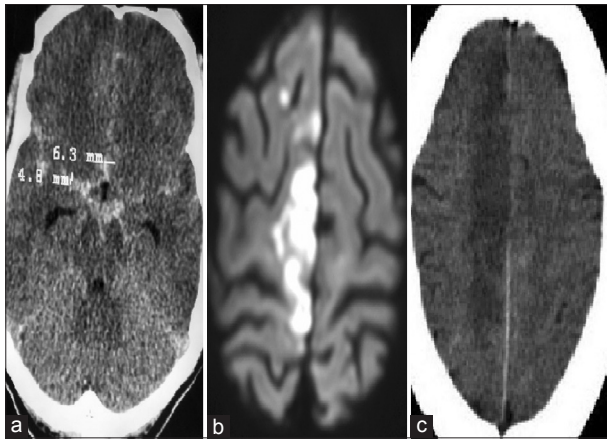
(a) Preoperative computed tomography scan of a patient showing subarachnoid hemorrhage with ruptured anterior communicating artery aneurysm. (b) Diffusion-weighted imaging showing diffusion restriction. (c) Postoperative computed tomography scan showing the right anterior cerebral artery infarct
